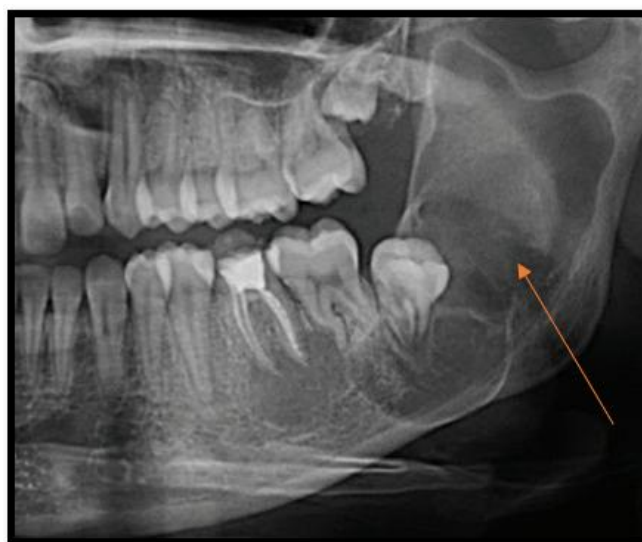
Radiographic image shows radiolucency in the posterior part of the mandible that indicates an odontogenic keratocyst. Source: Şen B, Dünder N, Aslan E, Işık G, Özyiğit Büyüktalancı D, 2024 [8]
